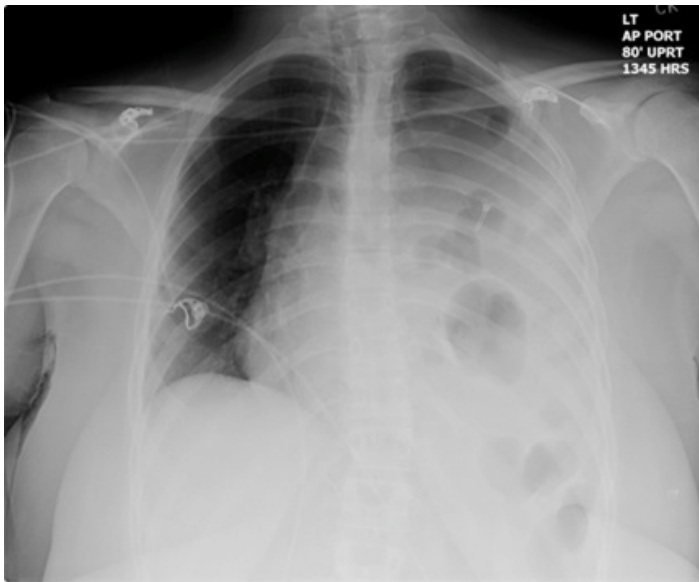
Portable chest radiograph obtained after needle thoracostomy, demonstrating near complete opacification of the left hemithorax with the presence of bowel loop.
